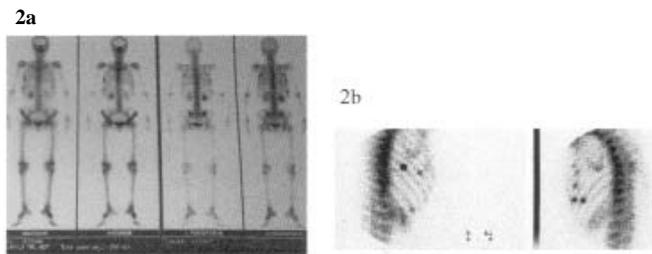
Shows multiple areas of increased uptake in several ribs on scintigraphy. The study dated November 29, 2000.
